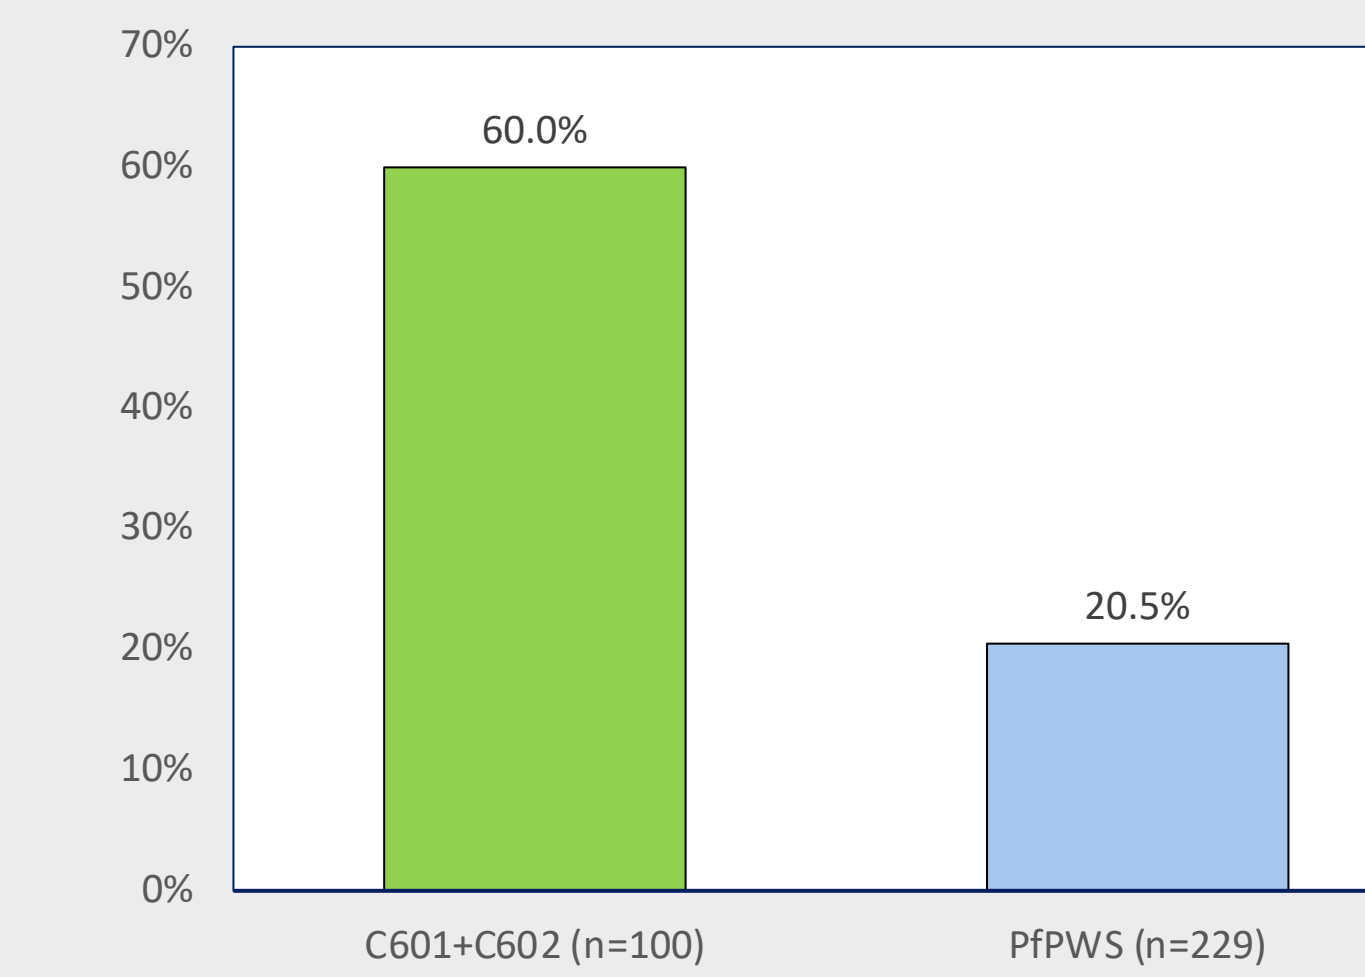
Responder Analysis – Percent of participants who had a decrease in hyperphagia scores of at least 7 points on the HQ-CT, at 6 months compared to baseline.
